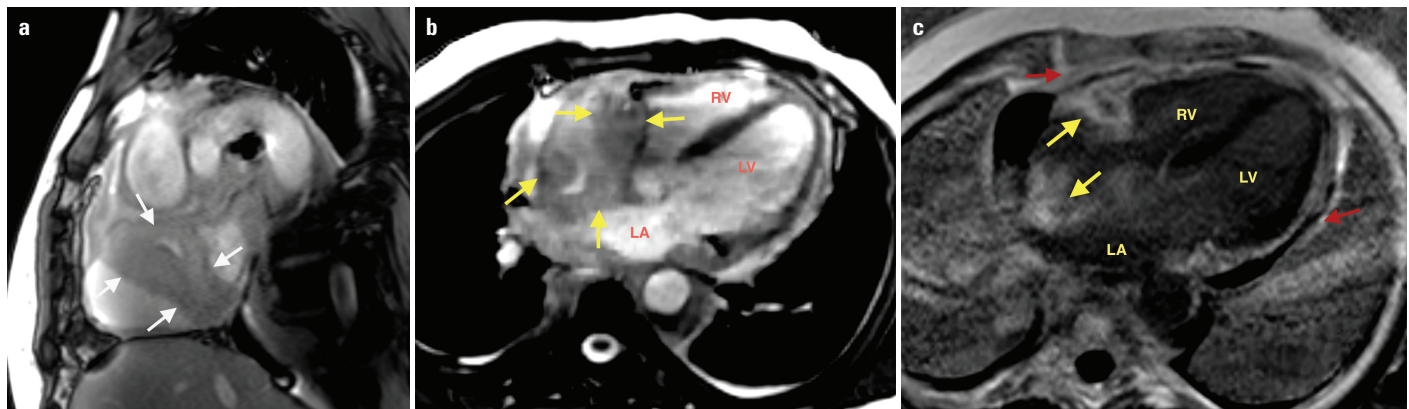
(a) Short axis GE (gradient echo) T2-weighted image shows a peripheral mass measuring 2–2.6 mm in thickness in the right atrium and atrial septum (white arrows). (b) Four-chamber GE T2-weighted image shows a peripheral mass comprising two separate parts (yellow arrows). Pericardial fluid and pericardial thickening were also observed. (c) Late gadolinium contrast-enhanced four-chamber image shows significant enhancement in the mass (yellow arrows) and both layers of the pericardium (red arrows)
